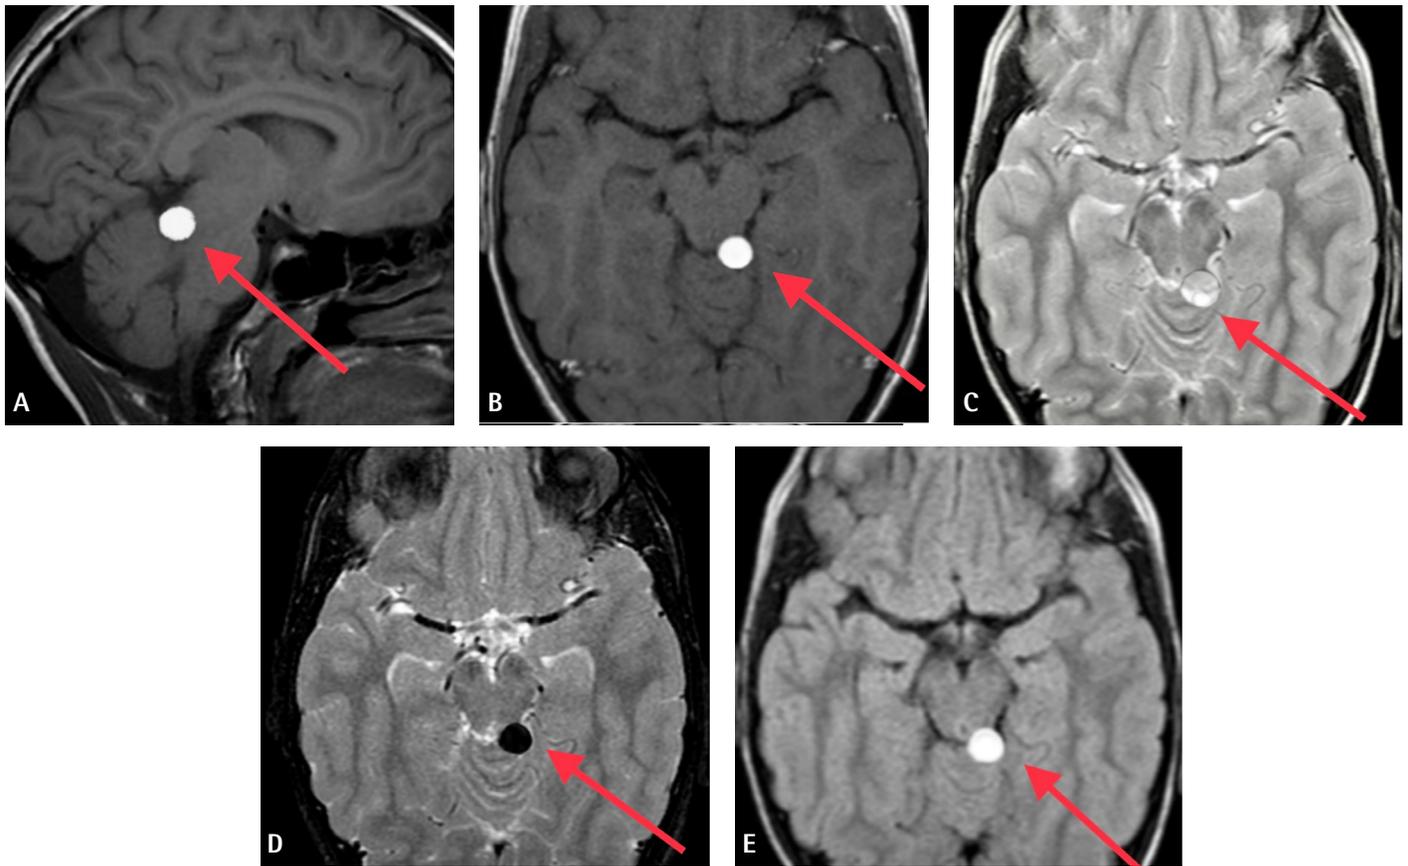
MRI images of the lipoma of the quadrigeminal cistern (the lesion is shown with a red arrow). (A) Sagittal T1, (B) axial T1, (C) axial T2, (D) axial T2-fat sat, (E) axial T2 FLAIR
